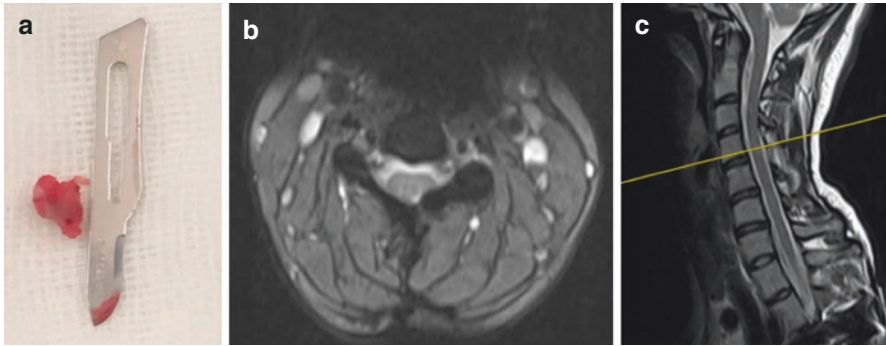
A 14-year-old female with a history of MHE and spinal osteochondroma at C4 lamina, postoperative: (a) Image of resected spinal osteochondroma. (b) Axial MRI four years after resection does not show recurrence. (c) Sagittal MRI four years after resection does not show recurrence. [Courtesy of Prof. Alpaslan Şenköylü]
